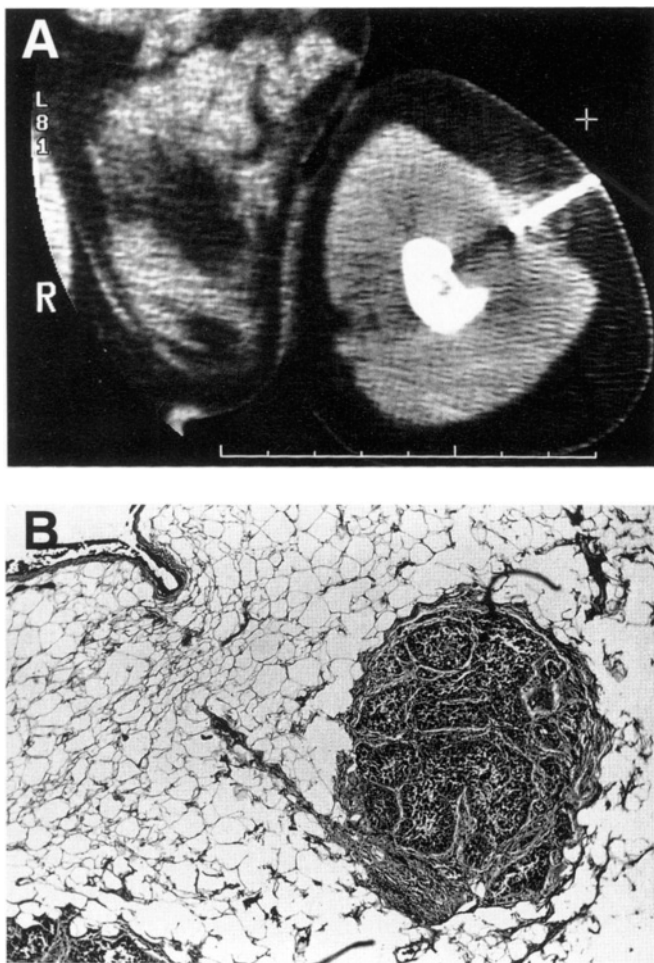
(A) Computed tomography guided core needle biopsy of a lytic lesion of the distal humerus, suspected of being a metastatic malignant melanoma. (B) That patient underwent resection–curettage and cryosurgery, followed by radiation therapy. The biopsy tract was resected en-bloc and its pathological evaluation revealed a tumor deposit.
